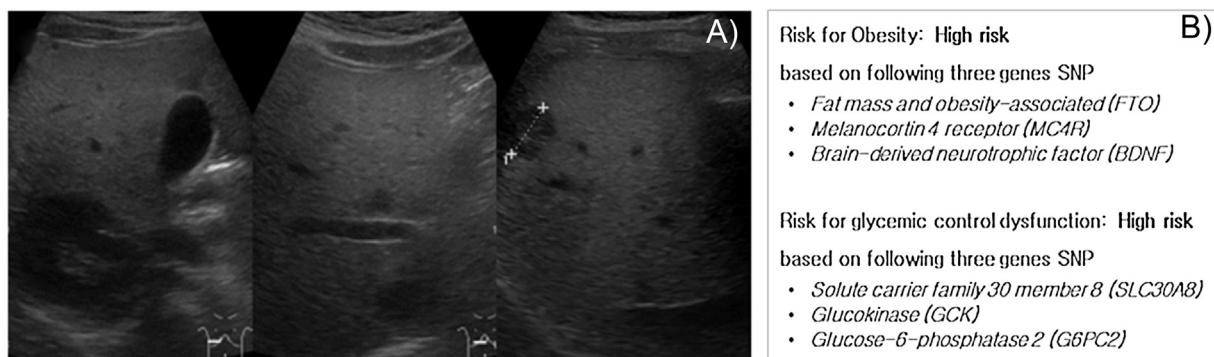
Sonographic finding in liver. The moderate fatty liver and a hemangioma and multiple cysts were found in abdominal nosography (A), and SNP analysis showed the vulnerable feature for fat and glucose metabolism (B).
